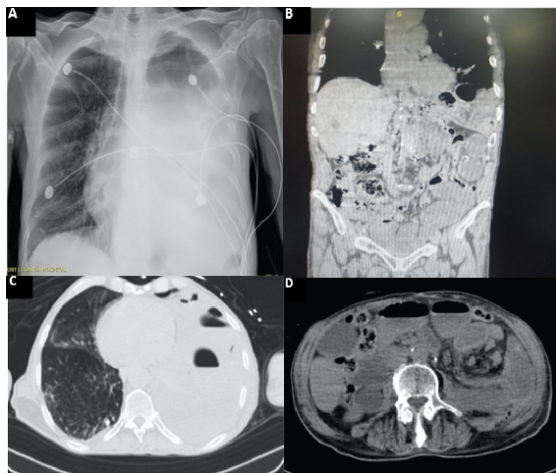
Left diaphragmatic hernia. A: Chest X-ray with visceral herniation in the chest and mediastinal shift. B: CT, coronal view with small bowel in left side of chest. C: CT, transverse view: Left diaphragmatic hernia containing small bowel loops with sub-pleural air bubbles. D: CT, transverse view: swirl sign of the mesentery (whirlpool sign) and associated proximal small bowel dilatation in the left hemi-thorax.
